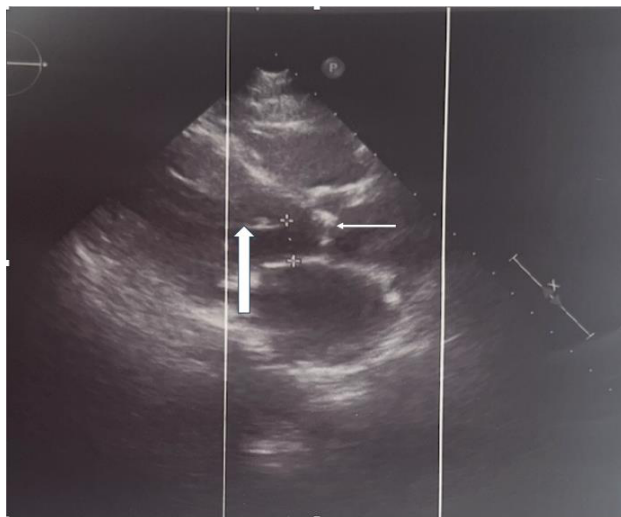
Two-dimension Transthoracic Echocardiogram in parasternal long axis view showing hypertrophied IVS (thick arrow) causing obstruction to LVOT. Thickened and calcified aortic valve leaflets are also visualized. (thin arrow)
